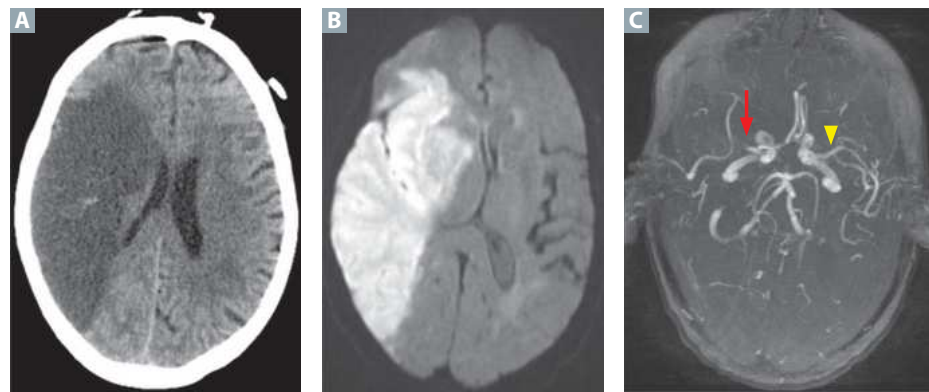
Acute ischemic stroke. Acute left hemiparesis in a 62-year-old woman. (A) Noncontrast head CT with loss of gray and white matter differentiation, cortical effacement, and asymmetrically decreased size of the right lateral ventricle in a right middle cerebral artery (MCA) distribution (indicating mass effect). (B) Diffusion-weighted MRI with reduced diffusion in the same distribution, consistent with an acute infarct. Diffusion-weighted sequences are the most sensitive modality for diagnosing an acute ischemic infarct. (C) Magnetic resonance angiography (MRA) shows the cause: an abrupt occlusion of the proximal right MCA (red arrow) compared with the normal left MCA (yellow arrowhead). Note pronounced midline shift evident on both MRI and MRA. (Reproduced with permission from USMLE-Rx.com)
